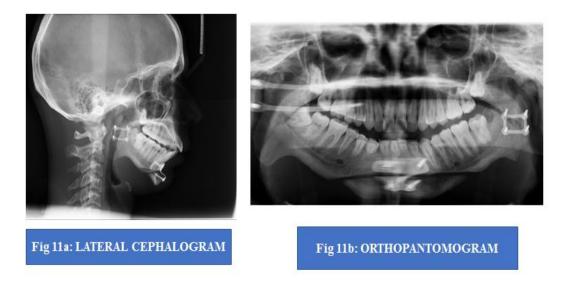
3RD MONTH RADIOGRAPH
